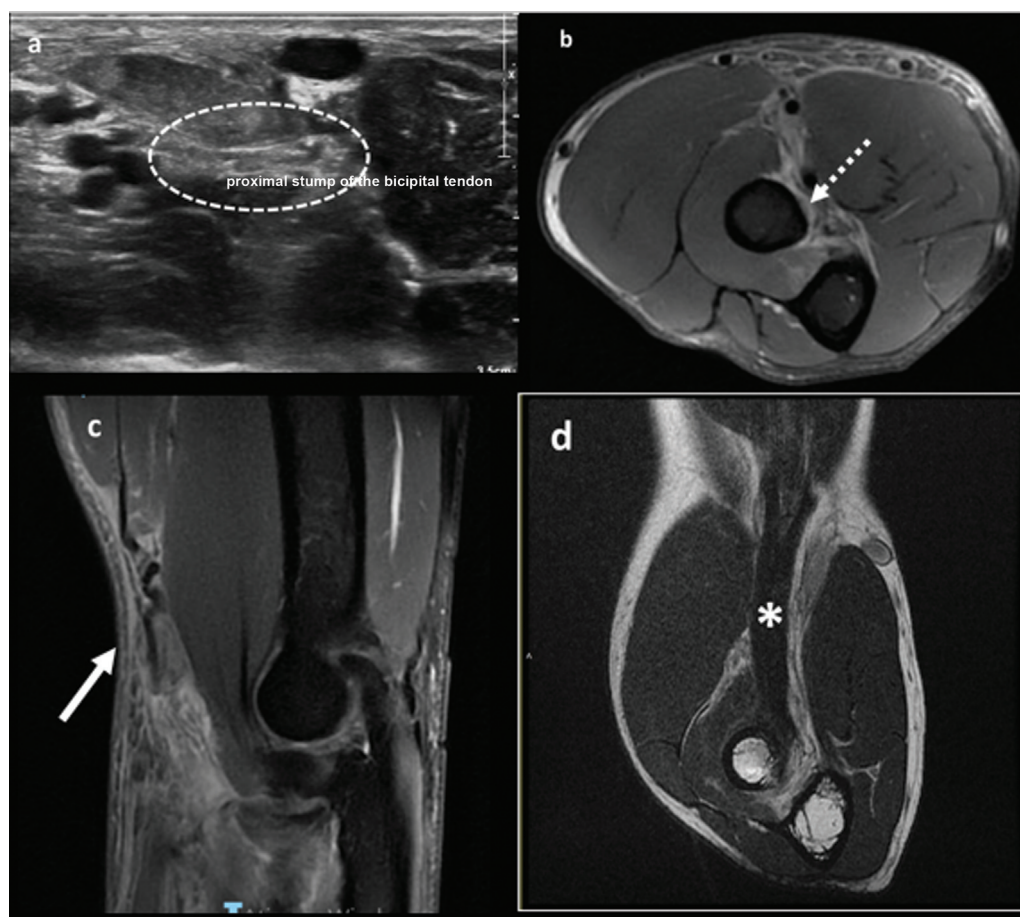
Imaging assessment of the distal biceps tendon Note: a) T2-weighted sagittal magnetic resonance imaging: complete lesion of the distal biceps tendon and its proximal retraction (arrow); b) T2-weighted axial section: detachment of the biceps tendon from its “footprint” on the radial tuberosity; c) Longitudinal ultrasound section identifying the tendon injury (dotted area) and tendon retraction at the level of the humeroradial joint (asterisk); d) Magnetic Resonance Imaging in FABS view (flexion, abduction and supination) weighted in T1 demonstrating the entire length of the distal biceps tendon (from the distal myotendinous transition to its insertion in the radial tuberosity - arrow) in the post-operative reinsertion
